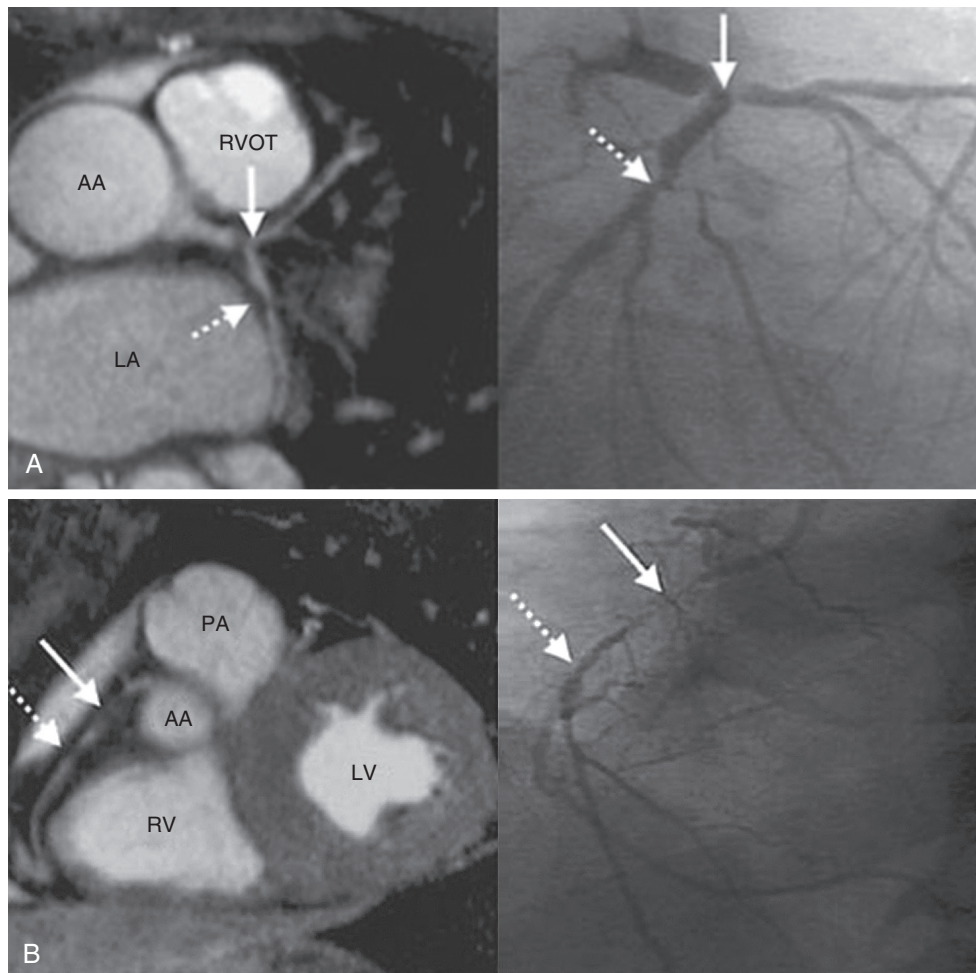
■ Coronary artery disease. A, Coronary cardiovascular magnetic resonance image with a three-dimensional gradient-echo sequence (left) and a corresponding radiographic coronary angiogram (right) indicate a severe lesion at the bifurcation of the left main coronary artery (solid arrows) and a more distal focal stenosis of the proximal left circumflex coronary artery (broken arrows). B, A coronary cardiovascular magnetic resonance image (left) and a corresponding radiographic angiogram (right) indicate two stenoses of the proximal (solid arrows) and middle (broken arrows) right coronary artery. AA, Ascending aorta; LA, left atrium; LV, left ventricle; PA, pulmonary artery; RV, right ventricle; RVOT, right ventricular outflow tract. (From Kim WY, Danias PG, Stuber M, et al: Three-dimensional coronary magnetic resonance angiography for the detection of coronary stenoses. *N Engl J Med* 345:1863-1869, 2001; with permission.)
